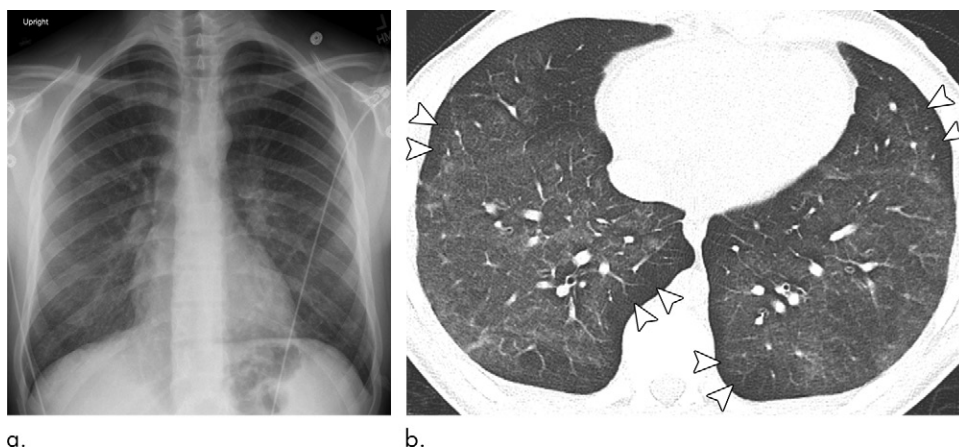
Images in a 16-year-old boy with 2-year history of daily nicotine and tetrahydrocannabinol vaping presented with 1.5 weeks of cough, shortness of breath, nausea, and vomiting. (a) Posteroanterior digital chest radiograph from day of presentation shows bilateral symmetric ground-glass opacities with lower lobe predominance. (b) Axial lung window (width, 1500; level, -700) image of noncontrast chest CT performed 1 day after presentation demonstrates bilateral ground-glass opacities with subpleural sparing (arrowheads).
